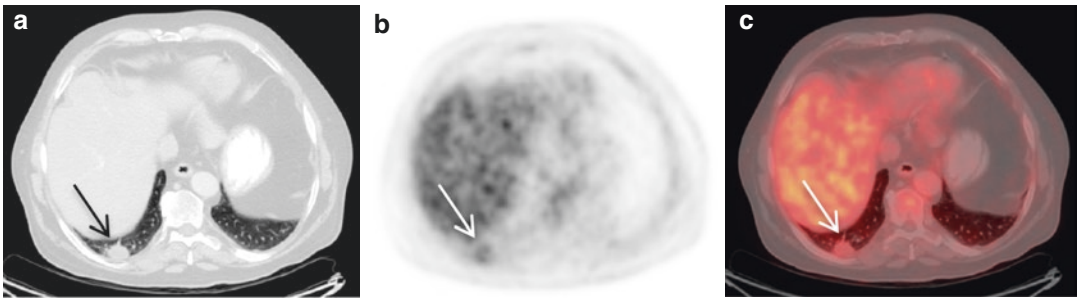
Clear cell renal cancer with lung metastasis. (a) CT component of FDG PET/CT scan shows a 2-cm solitary right lower lobe pulmonary nodule. (b) FDG PET demonstrates intense uptake. SUVmax 6.4. (c) Fused FDG PET/CT
